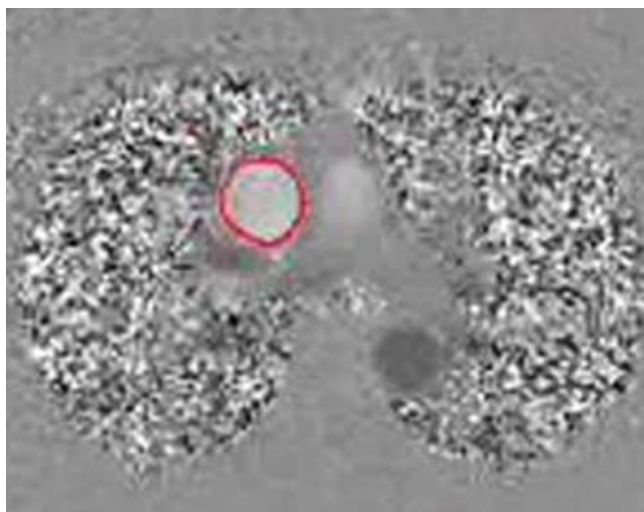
On a velocity phase-contrast MR image, orthogonal measurements of the ascending aorta at the level of the pulmonary bifurcation (outlined in red) can be performed.
